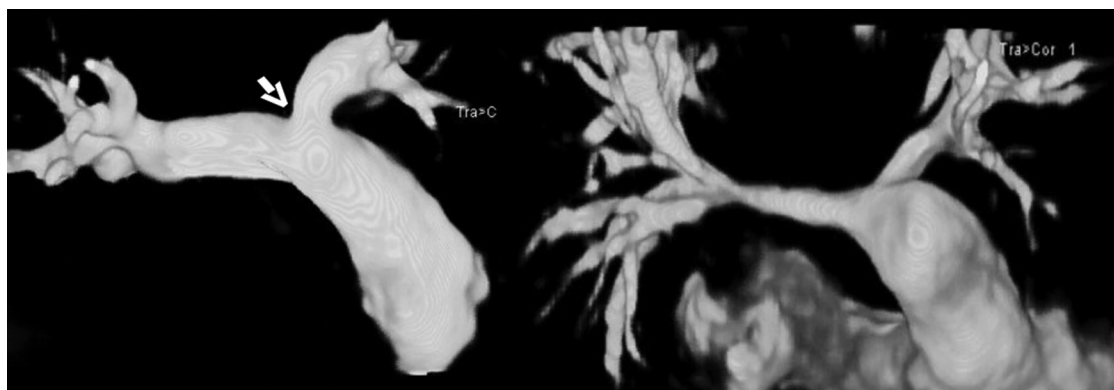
FIGURE e62-9 This panel shows two cases of peripheral pulmonary artery stenosis as seen on MRI. The one on the left shows a central proximal left pulmonary artery stenosis (*arrow*), whereas the right panel shows diffuse stenosis of both branch pulmonary arteries.
